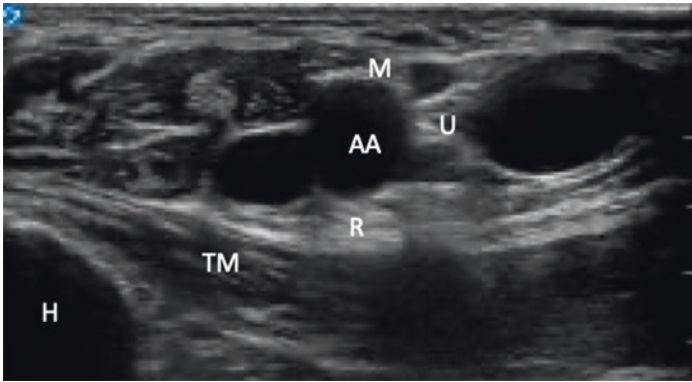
Axillary block, ultrasound image. Brachial plexus surrounding axillary artery at the level of the branches. AA, axillary artery. M median nerve, U ulnar nerve, R radial nerve, TM triceps muscle, H humerus
